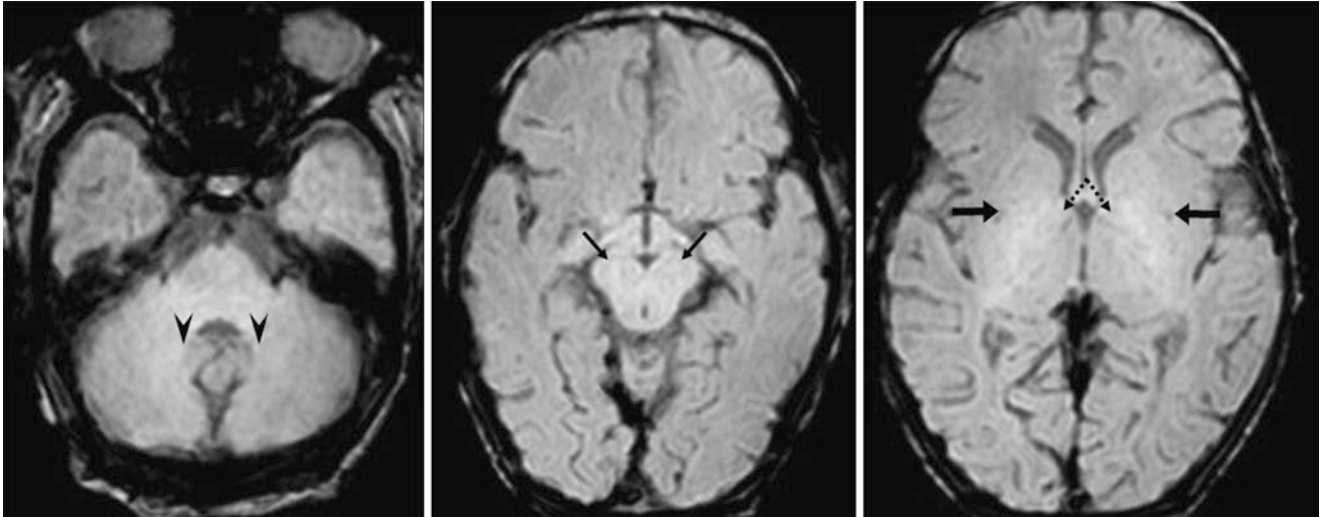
A 5-day-old patient who underwent a negative 3T MRI to evaluate for hypoxic-ischemic injury. The patient's milestones were normal on clinical examinations at 1 and 2 years of age. Axial SWI
